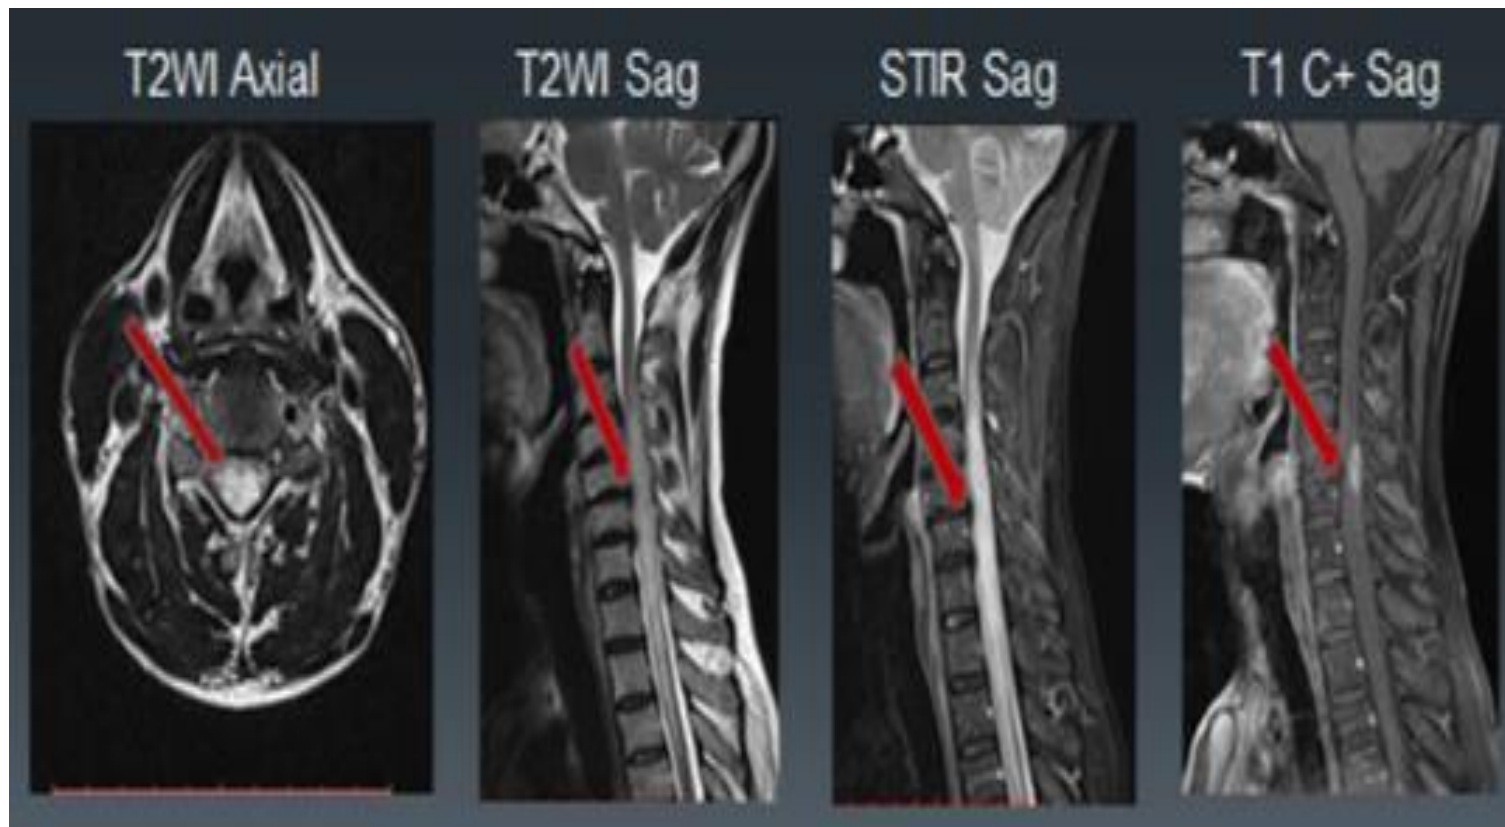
MRI of cervical spine showing axial & Sagittal T2 and STIR images. Shows homogenous hyperintensity (red arrow) mass lesion situated eccentric and posteriorly of spinal cord. Post-contrast axial T1wtd. MRI (C+). The same lesion with enhancement. So my radiological diagnosis is Astrocytoma.
